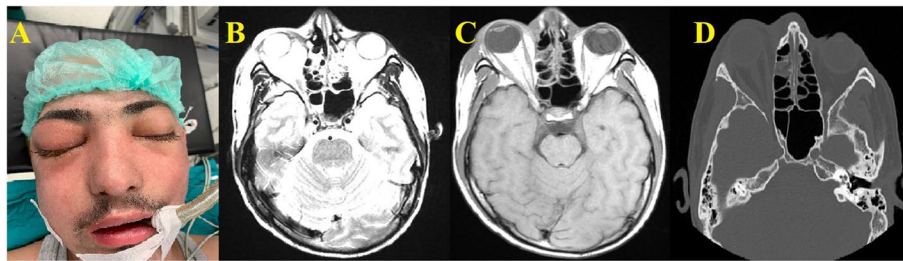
A case of invasive fungal rhinosinusitis with bilateral orbital involvement. A Appearance of the patient. B T2-weighted axial MRI image. C T1-weighted axial MRI image. D Axial paranasal CT image
